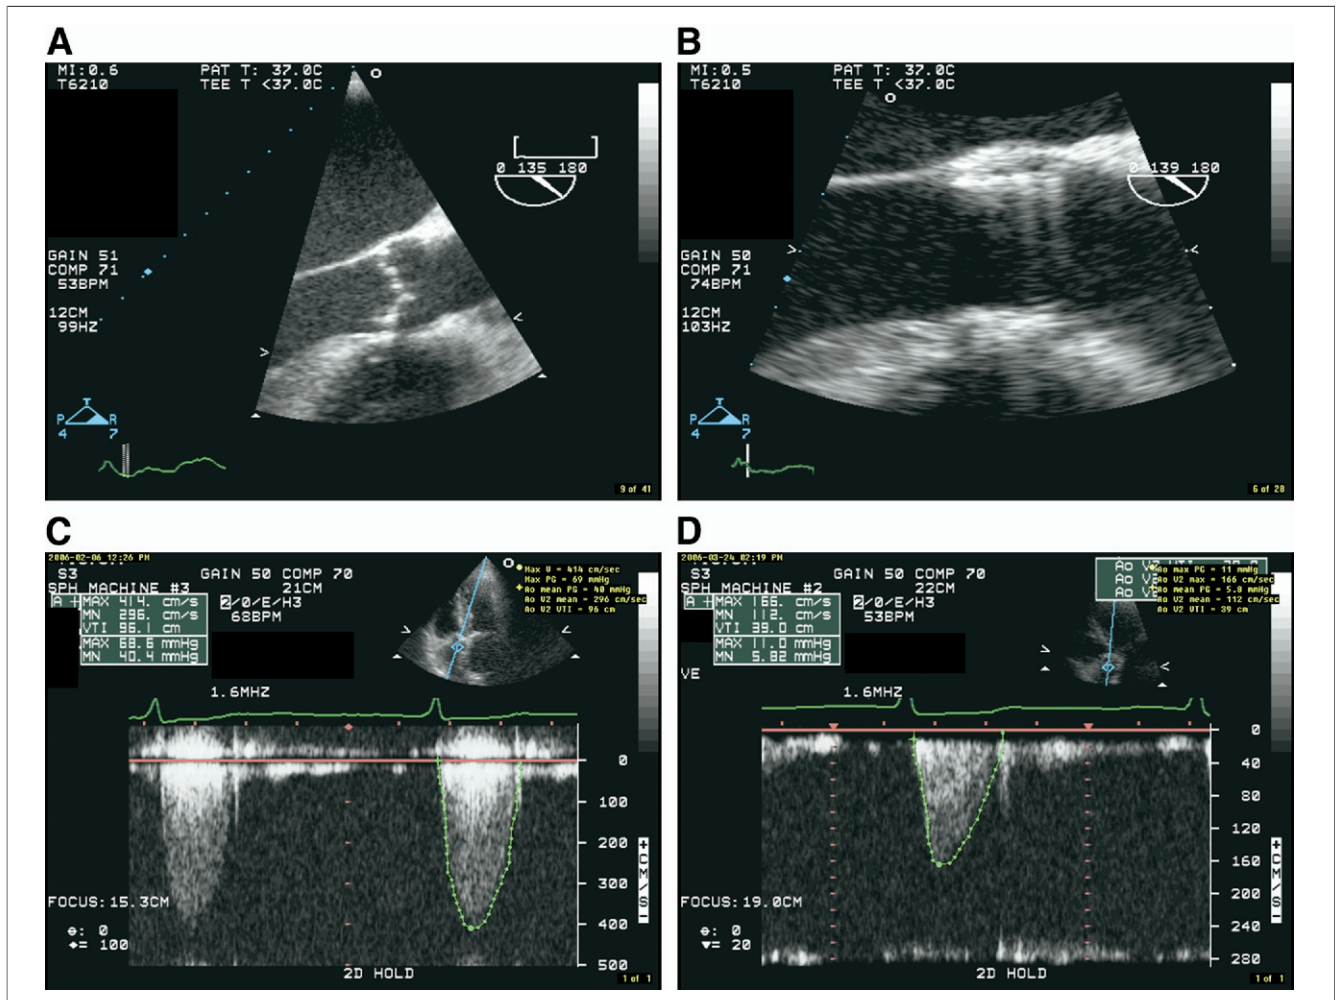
Early 2-Dimensional Appearances and Doppler Gradients After PHV Implantation
